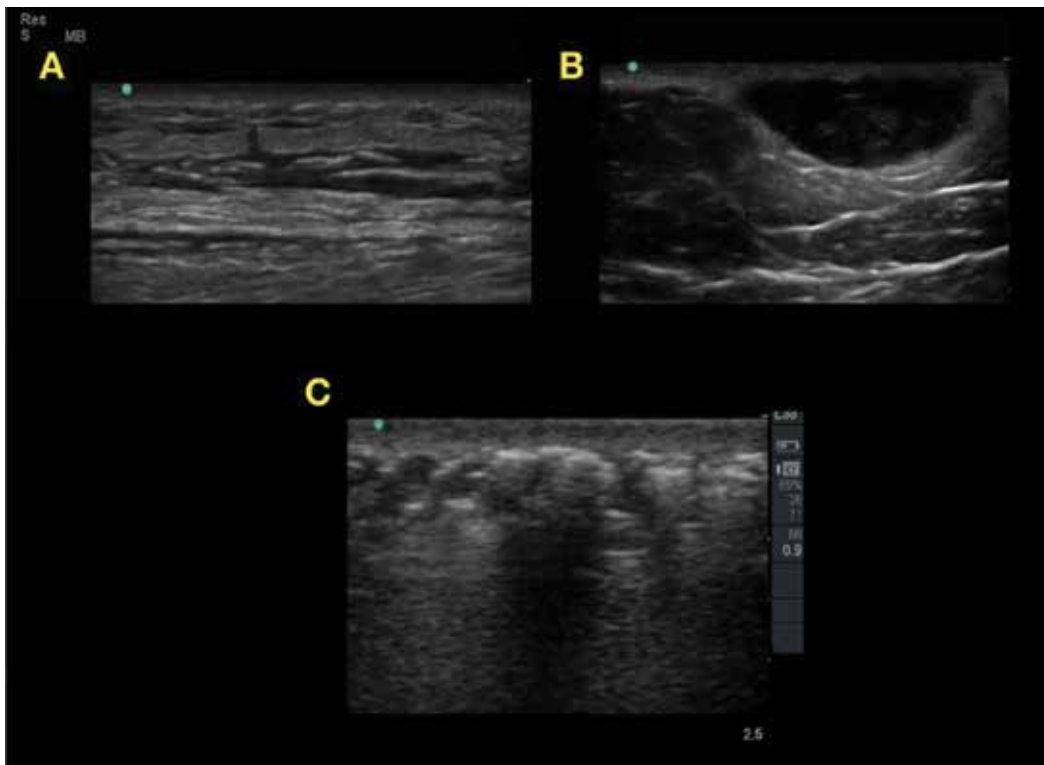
Soft tissue ultrasound demonstrating evidence of cellulitis (A), evident by increased echogenicity of the subcutaneous tissue separated by anechoic fluid appearing like cobble-stone. Case of abscess (B), evident by complex fluid collection mixed with debris. Case of necrotizing fasciitis (C) evident by subcutaneous thickening, fluid in the facial planes and air and shadowing.
